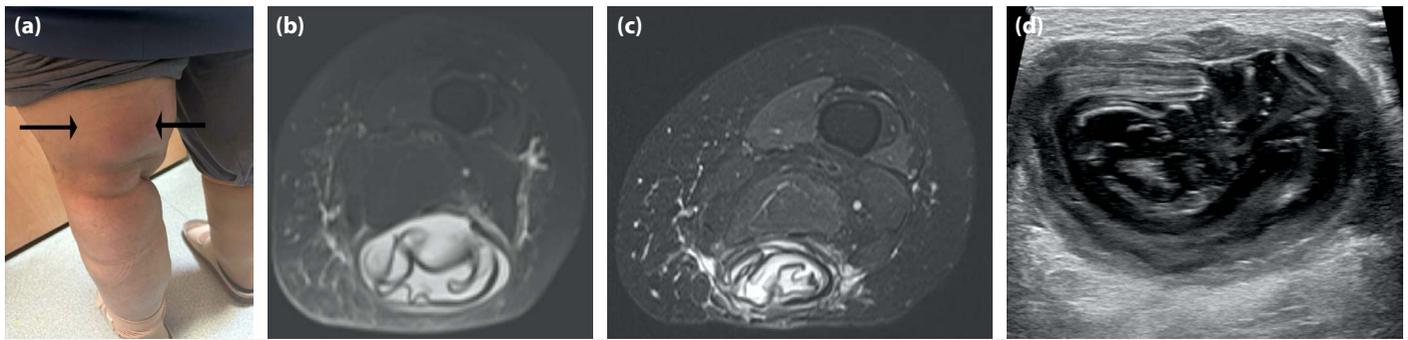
Image features of a hydatid cyst in the left thigh. (a) Physical examination findings at the time of admission. (b) Pre-procedural axial fat-suppressed T2-weighted magnetic resonance imaging (MRI) demonstrates a cystic lesion with a detached germinative membrane, classified as World Health Organization (WHO) cystic echinococcosis (CE) stage 3a. (c) Post-procedural axial fat-suppressed T2-weighted MRI demonstrates an 81% reduction in cyst volume, with further accentuation of detachment of the germinative membranes. (d) Post-procedural ultrasound image obtained using a linear transducer demonstrates the cystic lesion and the germinative membranes.
